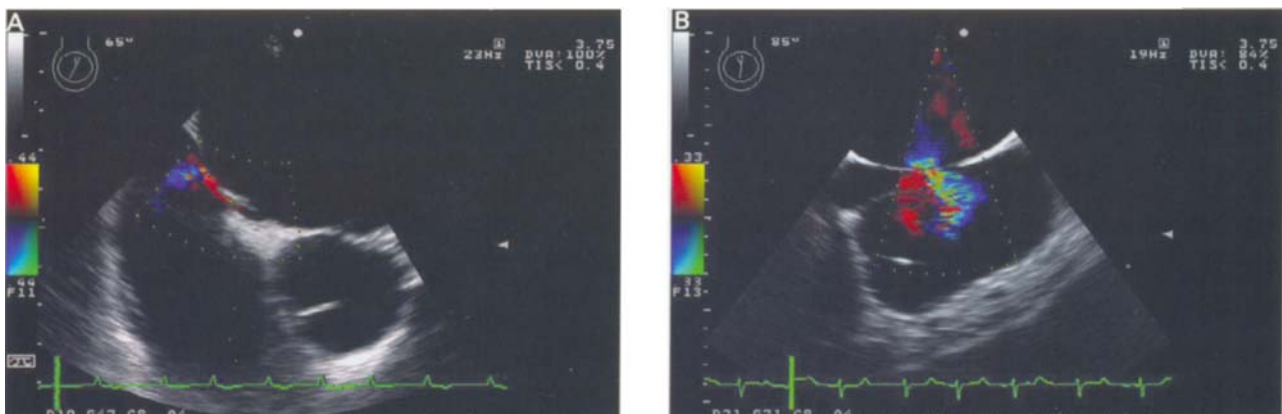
Atrial septal patent foramen ovale visualised in the mid-oesophageal (A) aortic valve short axis and (B) bicaval views. Colour flow Doppler shows left-to-right shunt flow.
